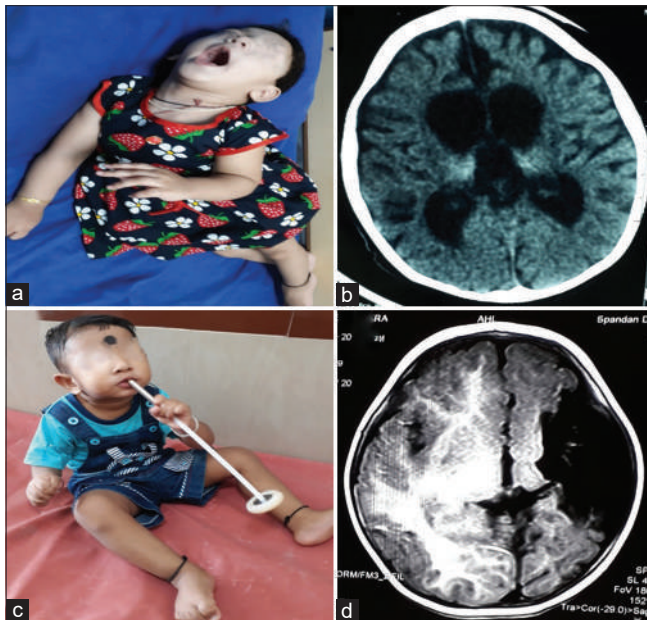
(a and b) Child with dystonic cerebral palsy with severe arching of back and neck due to dystonia and computed tomography (b) brain showing bilateral thalamic calcifications with cerebral atrophy with enlarged ventricles suggestive of hypoxic insult. (c and d): Child with hemiplegic cerebral palsy with magnetic resonance imaging (d) of brain showing porencephalic cyst.
